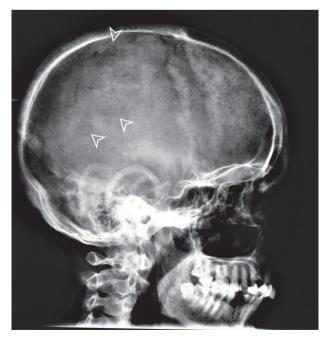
Follow up radiograph of the skull. Progressive healing of radiolucent lesions (arrows) is present.
